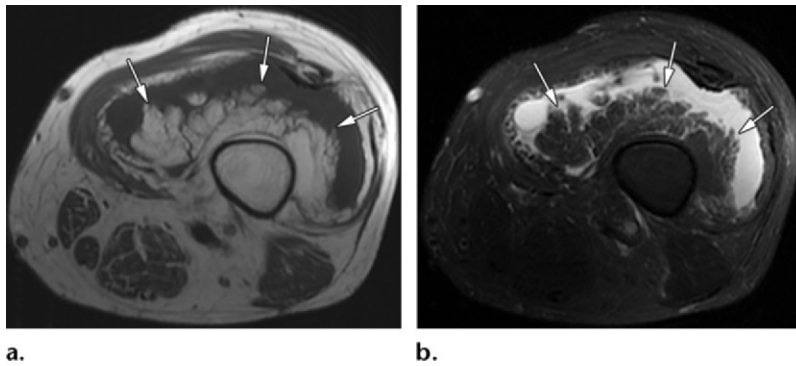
Lipoma arborescens of the knee in a 62-year-old man. (a) Axial T1-weighted MR image of the knee shows a frondlike lobulated fat-containing (hyperintense) mass (arrows) in the suprapatellar recess. (b) Axial fat-saturated T2-weighted MR image shows suppression (arrows) of fat signal intensity within the mass. Note the presence of a moderate joint effusion.
